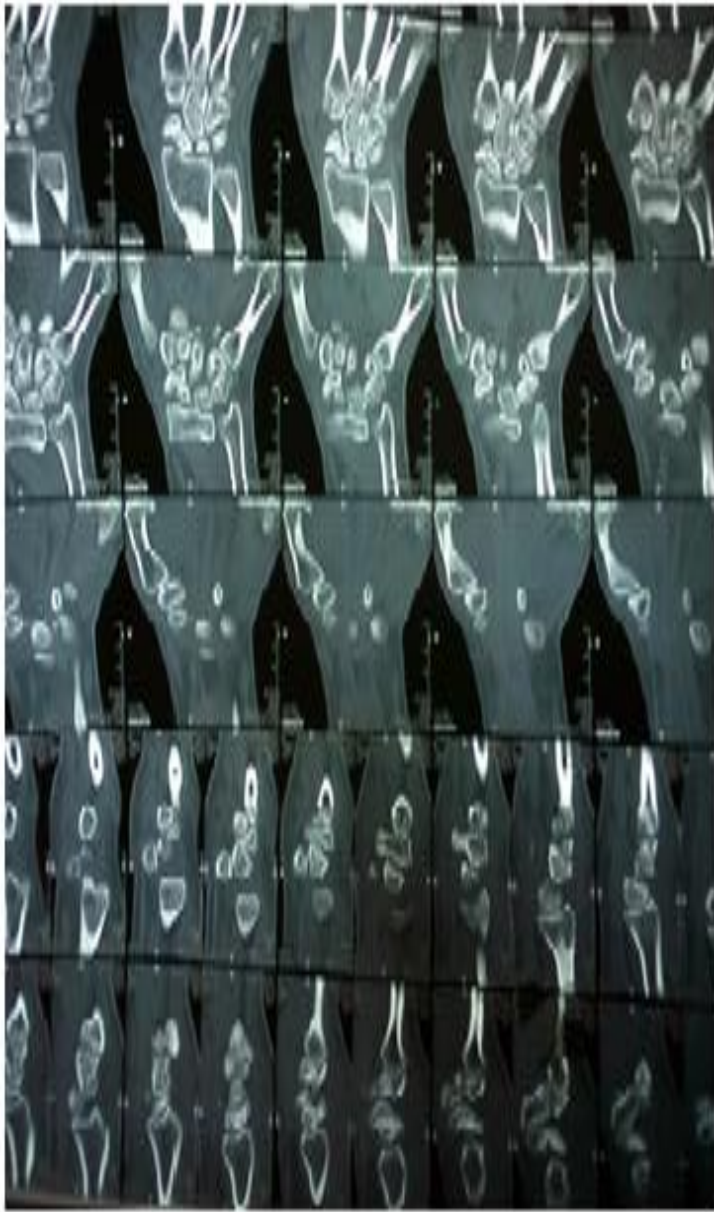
(a): CT of the left wrist
